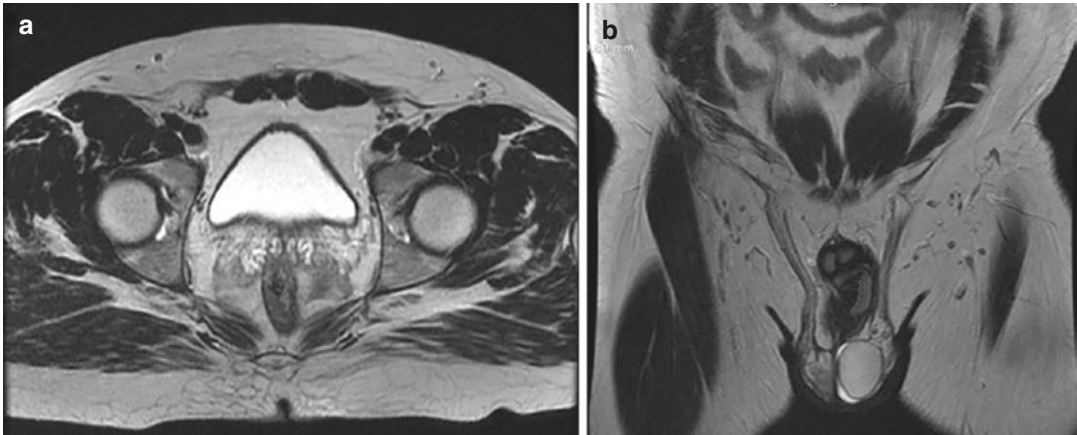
MR image of fat-containing right inguinal hernia in T2 axial (a) and coronal (b) views. Note the smaller fat-containing left inguinal hernia as well
